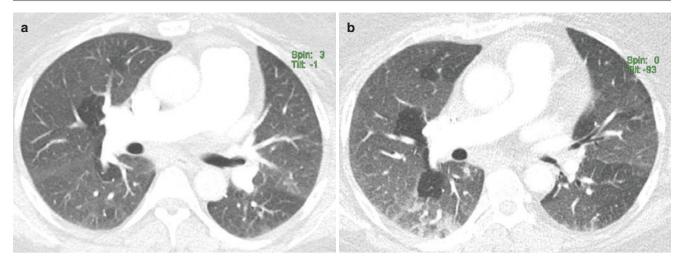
Pulmonary artery hypertension. (a) Inspiratory and (b) expiratory CT images show dilated central pulmonary arteries and low caliber vessels in lucent zones (under perfused). Note the lack of signs of large airway disease
